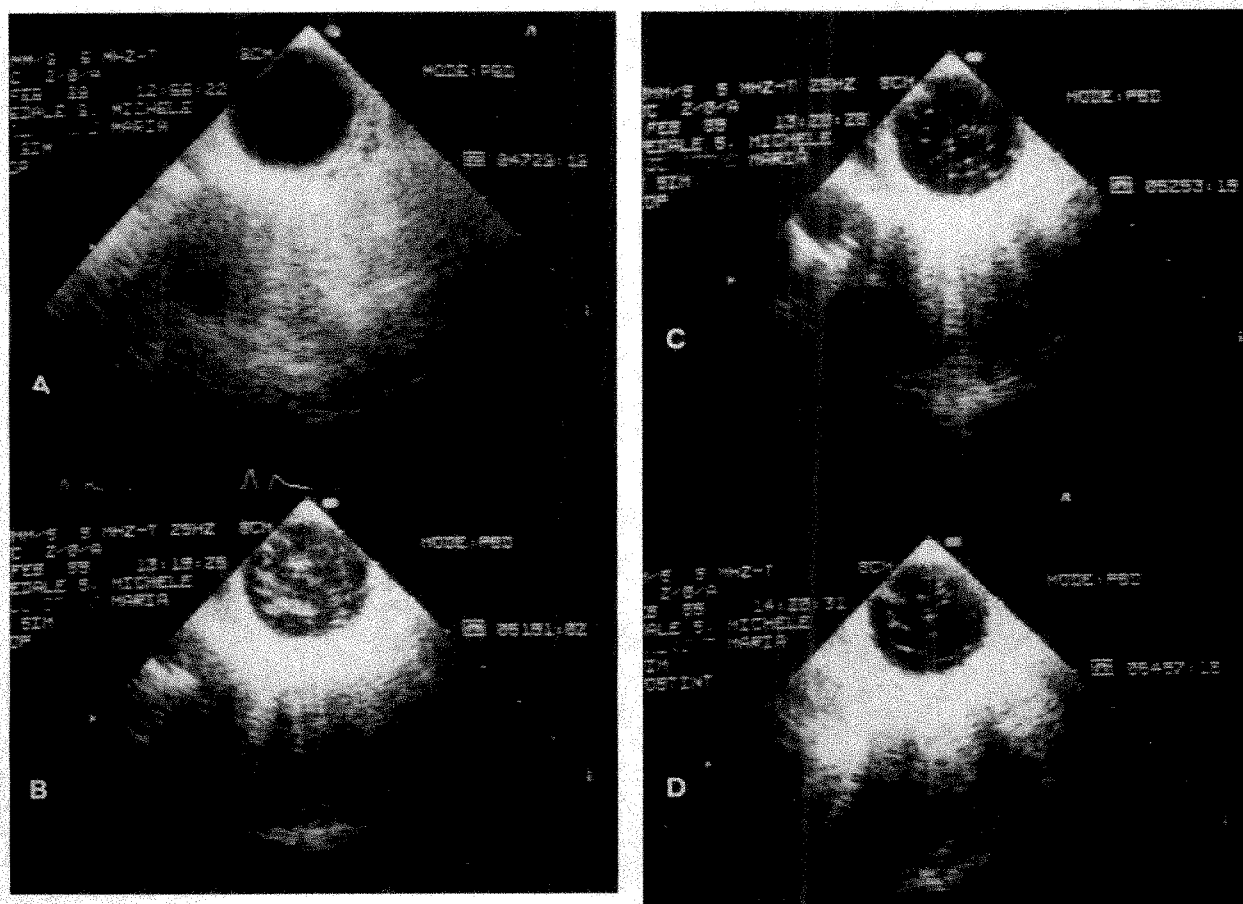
Bubble oxygenator. A, trans-esophageal cross-sectional view of descending aorta before start of cardiopulmonary bypass. B, echocardiographic contrast during infusion of priming solution at start of cardiopulmonary bypass. C, D, appearance of microbubbles lasting throughout cardiopulmonary bypass.
